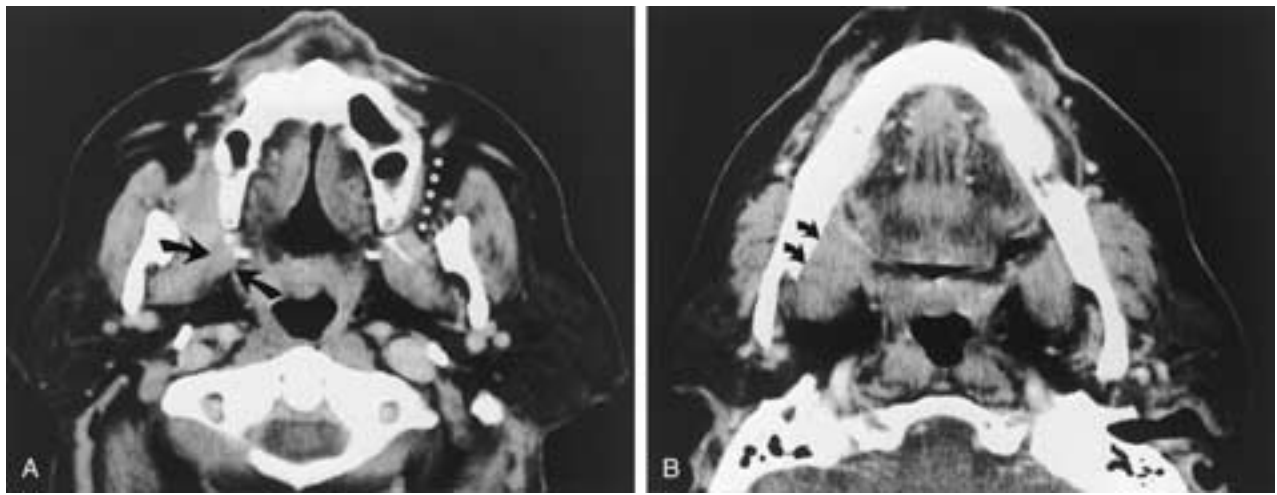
Retromolar trigone squamous cell carcinoma. A and B, Axial contrast-enhanced CT scans demonstrate a right retromolar trigone tumor invading the buccal space fat. The normal fat in this region on the left is indicated by the dots in A. Tumor also extends medial to the medial pterygoid muscle and obliterates the most anterior extension of the parapharyngeal space fat (*arrows* in A). The tumor extends along the pterygomandibular raphe to the mylohyoid line on the inner surface of the mandible (*arrows* in B).
